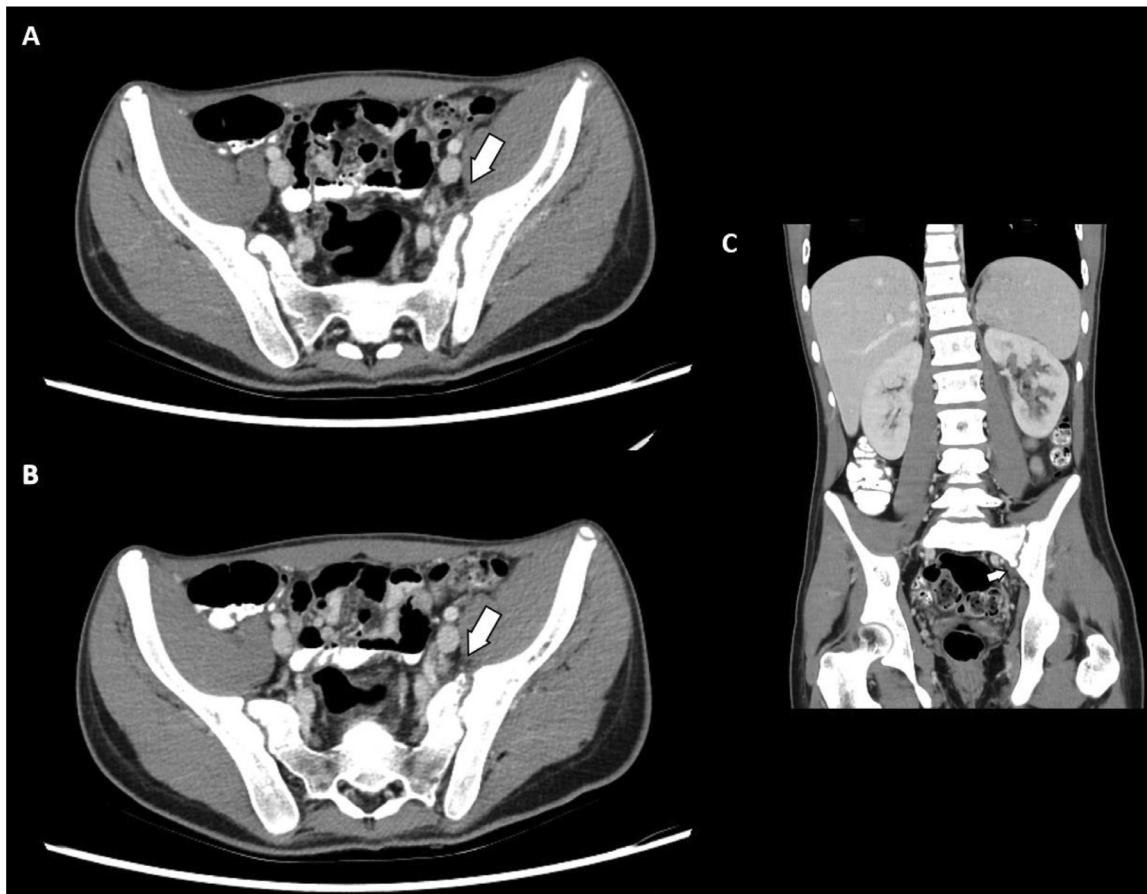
Computed tomography (CT) scan of abdomen and pelvis performed with intravenous contrast. Subtle asymmetric fat stranding and para-articular inflammation around the left sacroiliac joint seen on the axial (A, B) and coronal (C) views.
